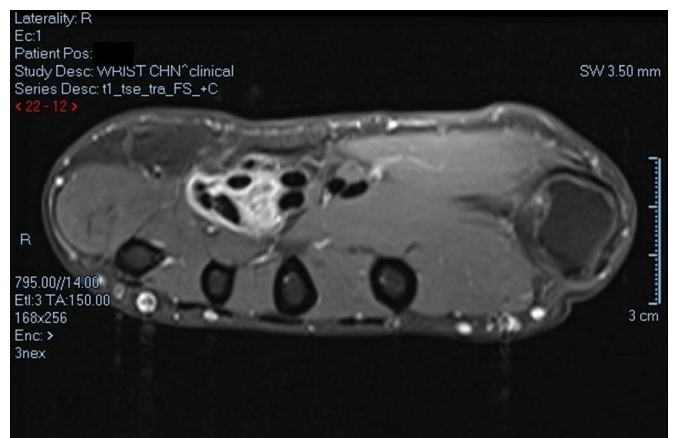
MRI image of 2.2 × 0.9 cm mass within the flexor digitorum profundus tendons of the third, fourth, and fifth digits. MRI, magnetic resonance imaging. [full color online](#)
